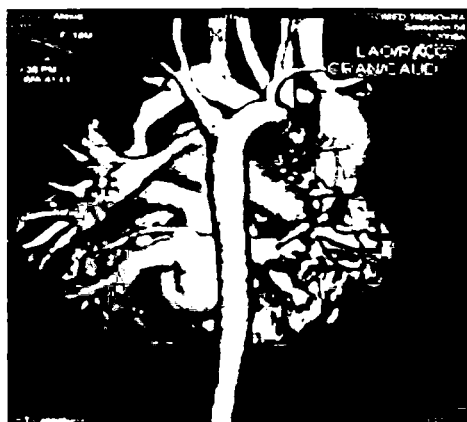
and Figure 1b. – CT images
